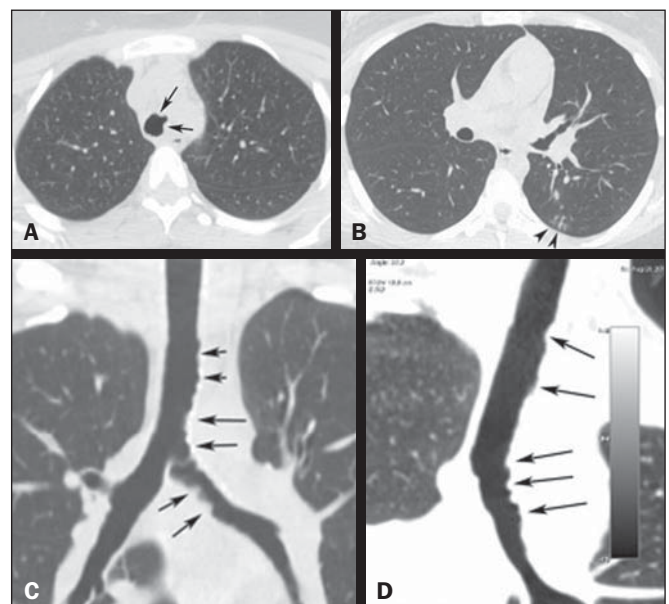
A: Axial CT slice showing irregular narrowing of the tracheal lumen (arrows). B: Axial CT slice showing centrilobular opacities, with a tree-in-bud aspect, in the lower lobe of the left lung, suggesting bronchiolar filling. C, D: Coronal and oblique coronal reconstructions showing irregular internal contours, together with parietal thickening (arrows), in the trachea and the left main bronchus.
